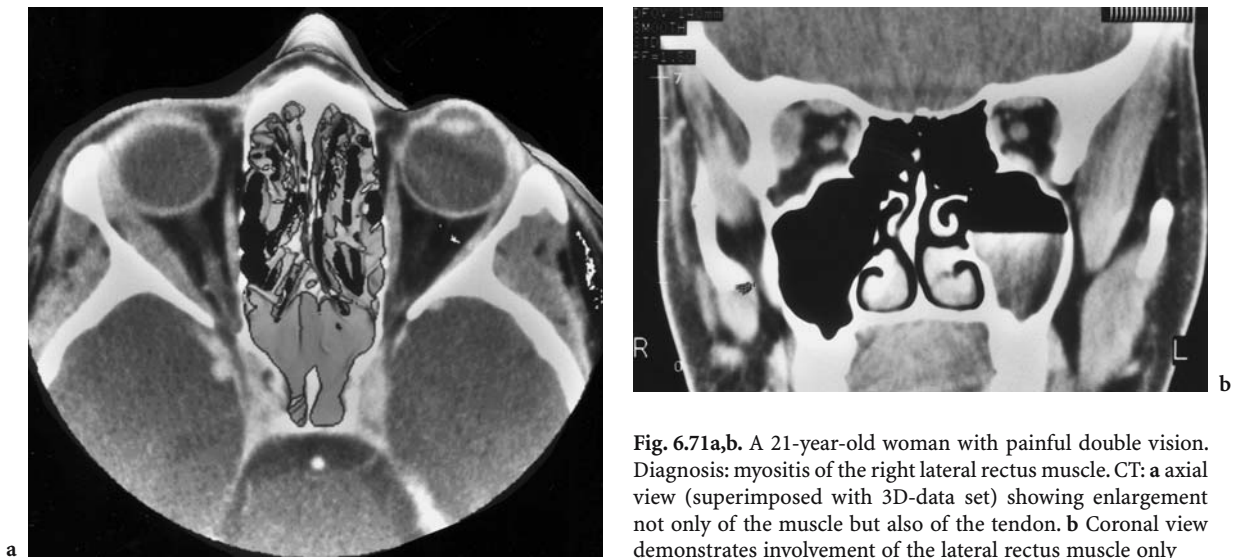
A 21-year-old woman with painful double vision. Diagnosis: myositis of the right lateral rectus muscle. CT: a axial view (superimposed with 3D-data set) showing enlargement not only of the muscle but also of the tendon. b Coronal view demonstrates involvement of the lateral rectus muscle only
